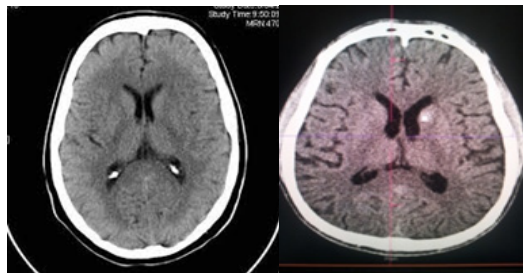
CT scan of the brain of a normal 26 year old male (Left). CT scan of the patient with cerebral brain atrophy (Right)
